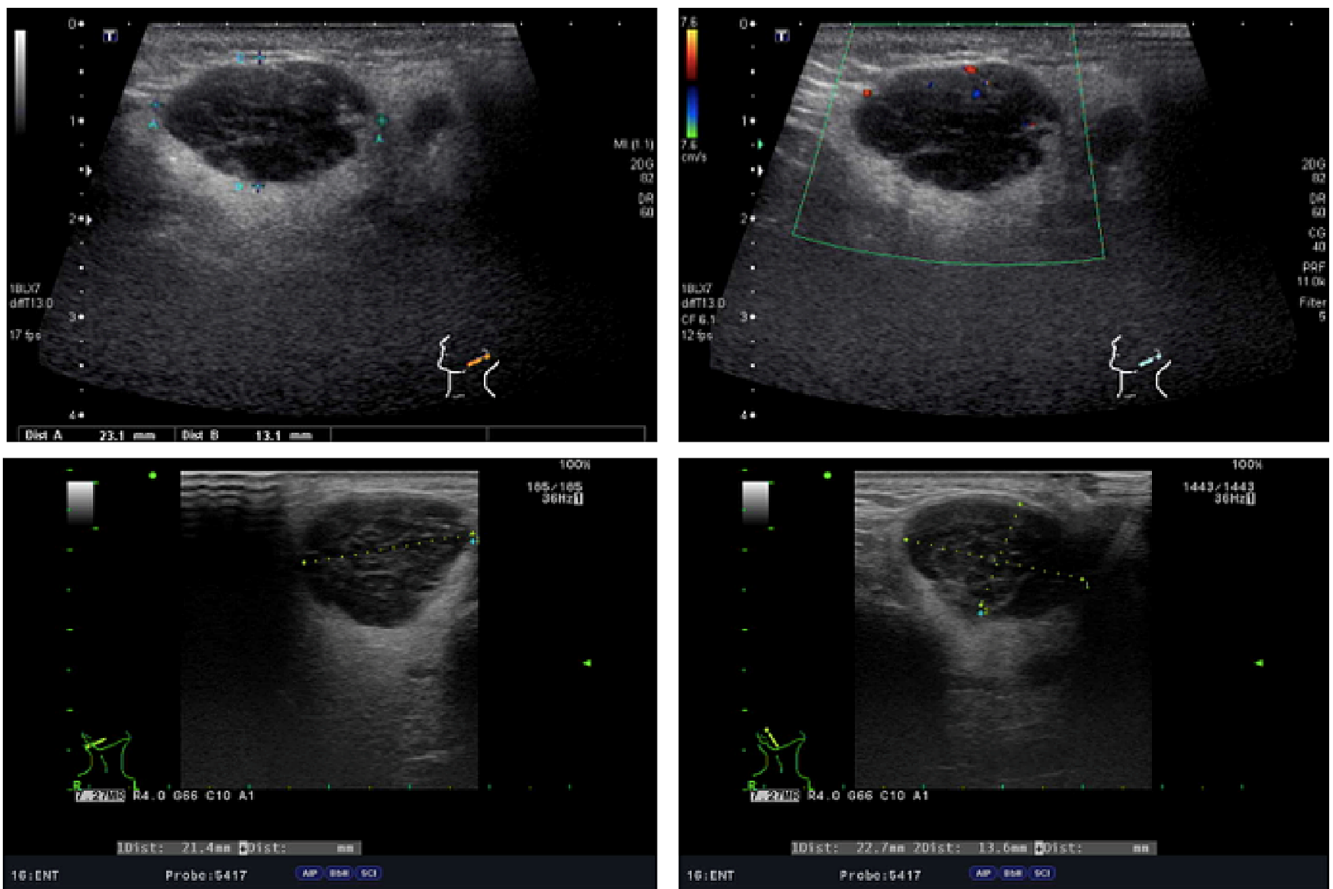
Ultrasonography findings. Two cases with ultrasonographic examinations showed that the lymphoepithelial carcinoma lesions are hypoechoic with a sharp margin and heterogenous content.
